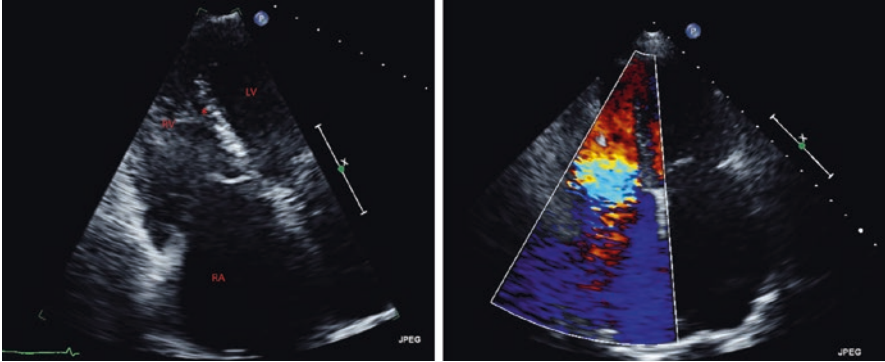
(a) Section of the apical four-chamber view showing dilated right atrium (RA), dilated right ventricle (RV) and *pacemaker lead placed in the RV. (b) There is severe (4+) tricuspid valve regurgitation caused by annular dilatation. There is a centrally directed regurgitant jet. The left atrial cavity is severely dilated. RV systolic tissue Doppler velocity is 13.1 cm/s. Tricuspid annular displacement is 1.8 cm
